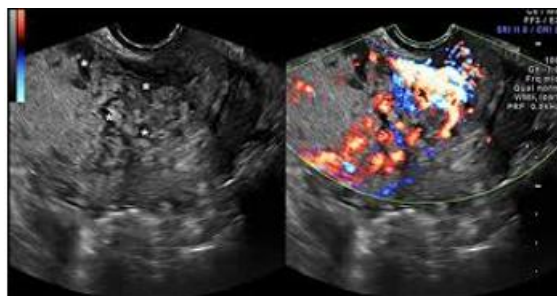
Transvaginal ultrasound image showing loss of the retroplacental clear zone with placental lacunae and increased Doppler flow (adapted from typical findings in placenta increta).
